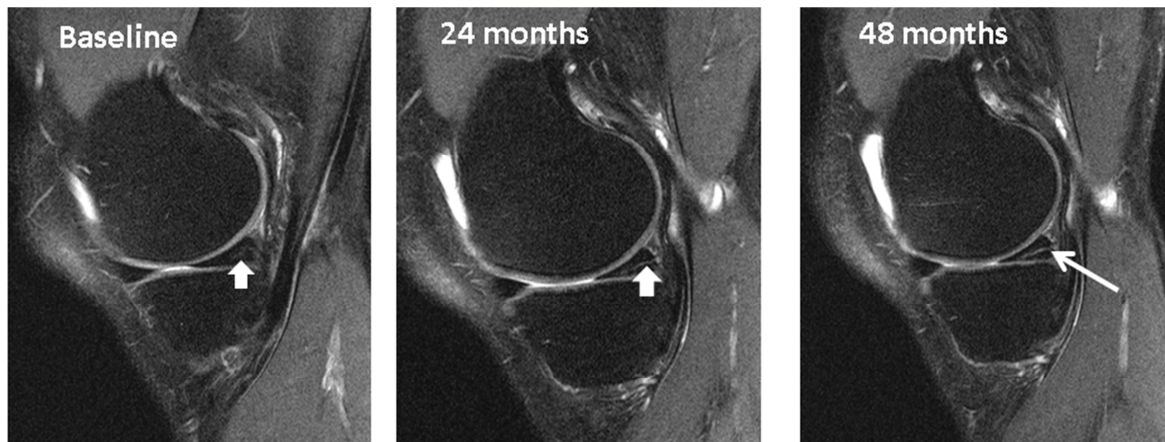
The development of intrameniscal signal into a horizontal cleavage lesion in the posterior horn of a medial meniscus over the period of 4 years captured on repeat 3-Tesla knee MRI.
